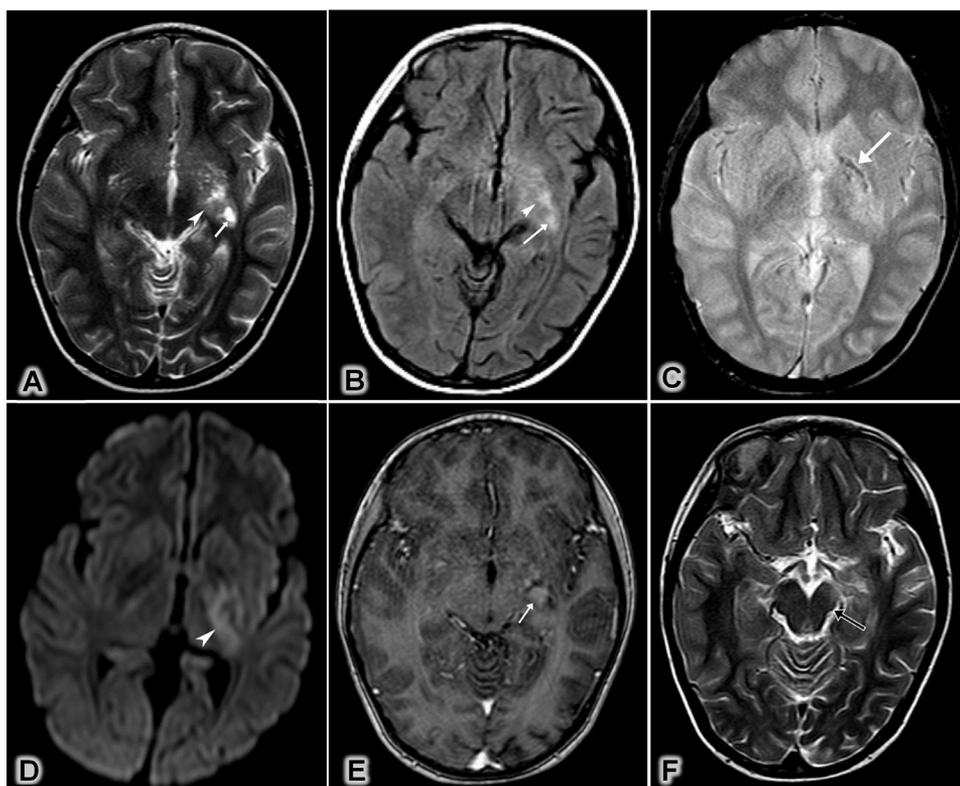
Case 2: MRI Images, including (A) axial T2W, (B) axial FLAIR, (C) axial T2*, (D) axial DWI, (E) postcontrast axial T1W, demonstrated. (A-B) Axial T2W and FLAIR showed A heterogeneous mass in the left lentiform nucleus comprising a solid portion (arrowhead) and a cystic portion (arrow). (C) Axial T2* showed a calcifying component (arrow). (D) DWI showed a restricted diffusion (arrowhead). (E) Axial T1W post-contrast showed heterogeneous enhancement (arrow). (F) Axial T2W image showed atrophy of the ipsilateral cerebral peduncle (black arrow).
